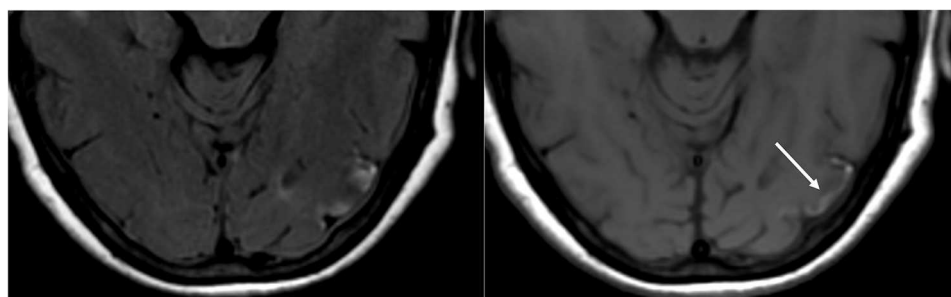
T2-FLAIR (left) image in a patient with uncontrolled hypertension and prior imaging indicating PRES (see Figure 6), now controlled and 6 weeks later, demonstrates resolution of the previously seen edema. Small areas of gliosis due to injury are seen in the left temporal lobe. Axial non-contrast T1 shows curvilinear cortical laminar necrosis related to the prior injury related to PRES. While PRES generally is fully reversible, it may result in permanent injury in some situations.
